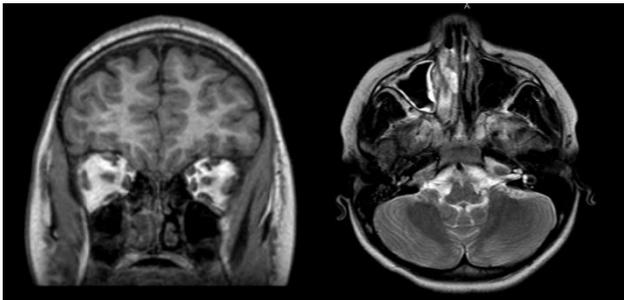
MRI head and neck with contrast.
